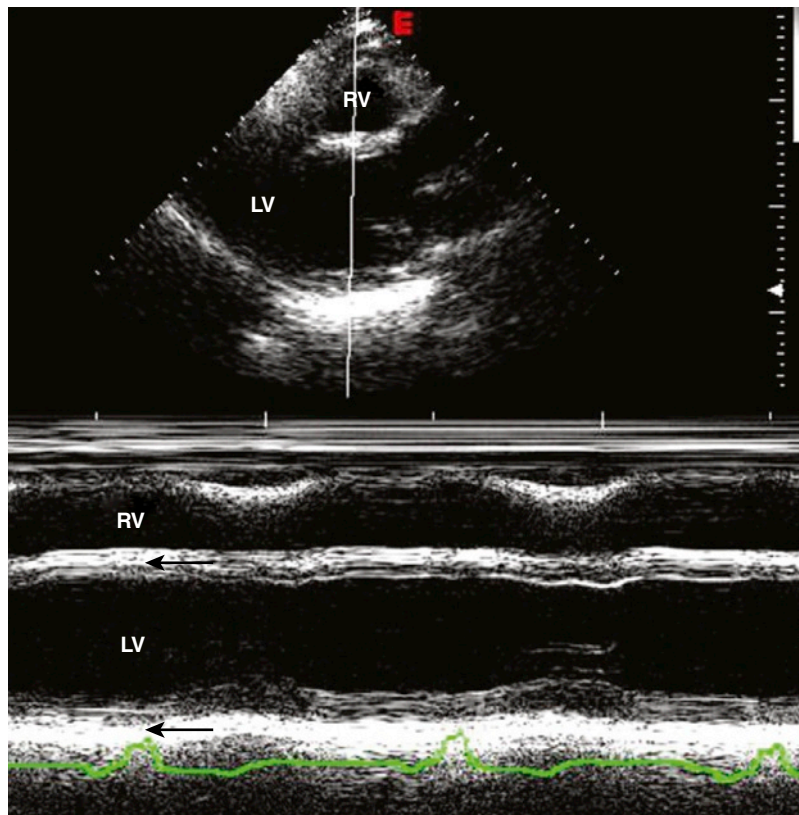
Echocardiography shows global hypokinesia (arrows) in cardiomyopathy due to Behçet's disease. LV, left ventricle; RV, right ventricle.
